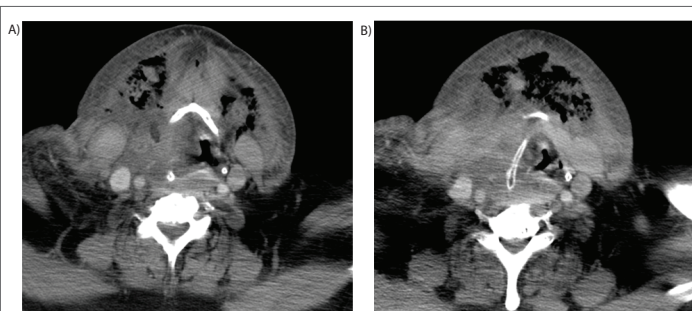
Axial CT scan images of the neck (A and B) showing marked gas in the submental region with diffuse oedema of the subcutaneous tissues, more so on the right, extending into the right parapharyngeal space and deviating the pharynx and larynx to the left with distortion of the glottis and supraglottis. No abscess collection, however, is seen.
